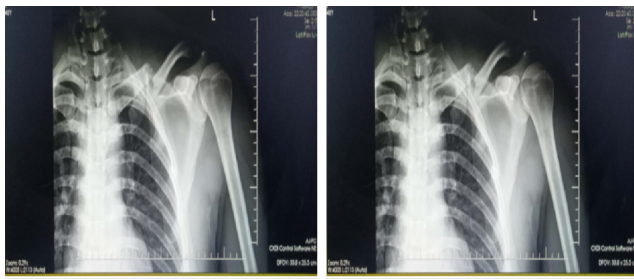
X-ray of a conservatively treated patient
